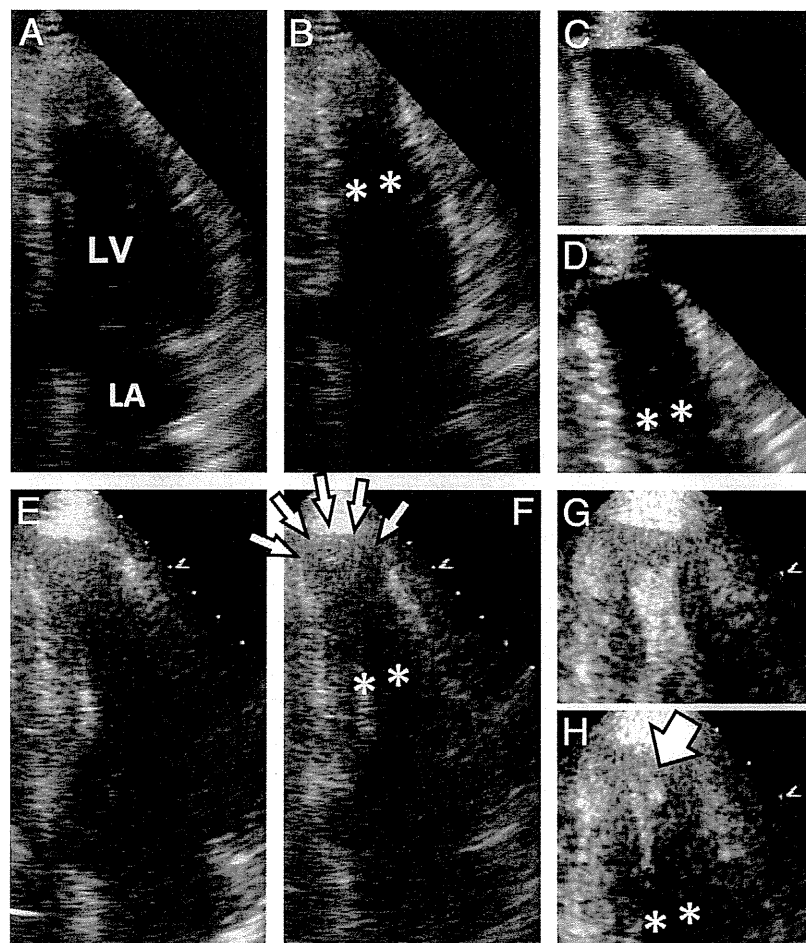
Echocardiographic Images of an HCM Patient in Whom an Apical Aneurysm Developed From MVO
